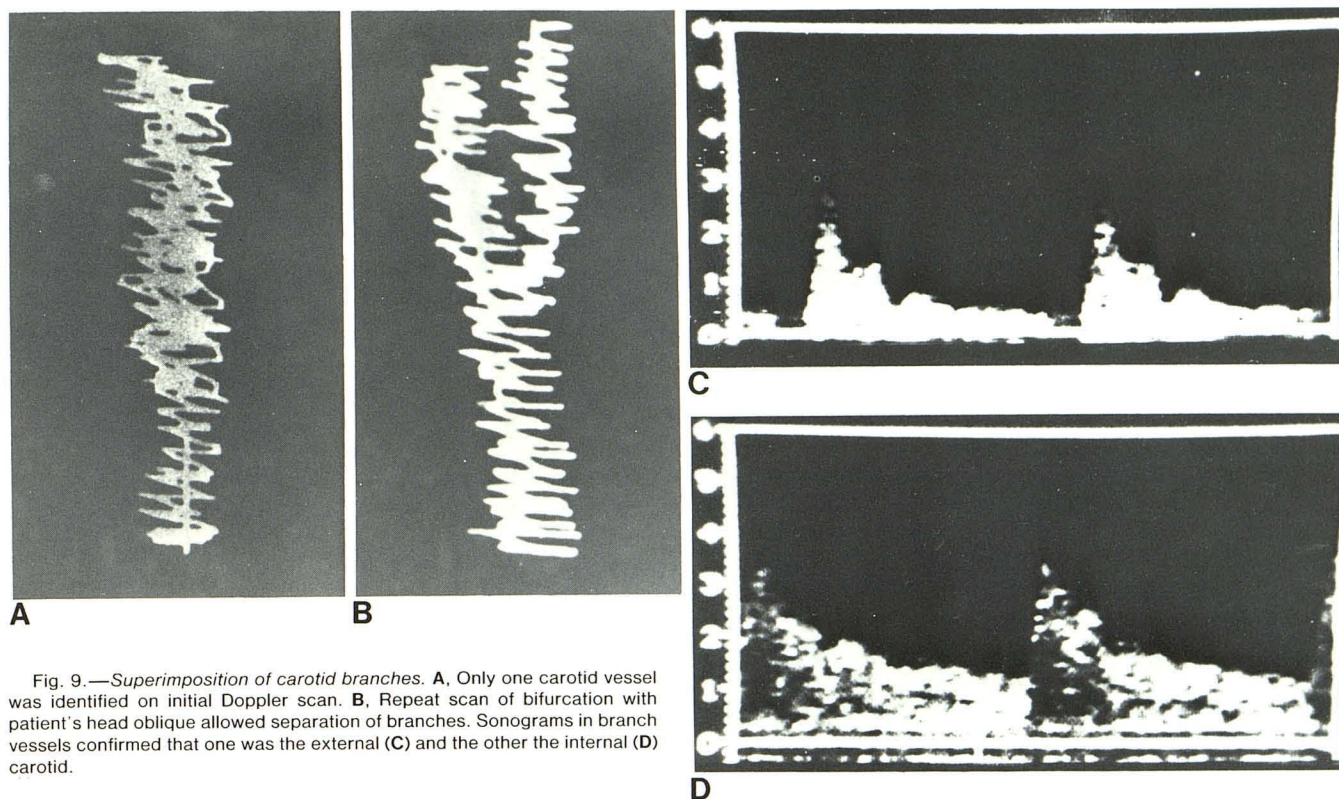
Superimposition of carotid branches. A, Only one carotid vessel was identified on initial Doppler scan. B, Repeat scan of bifurcation with patient's head oblique allowed separation of branches. Sonograms in branch vessels confirmed that one was the external (C) and the other the internal (D) carotid.
